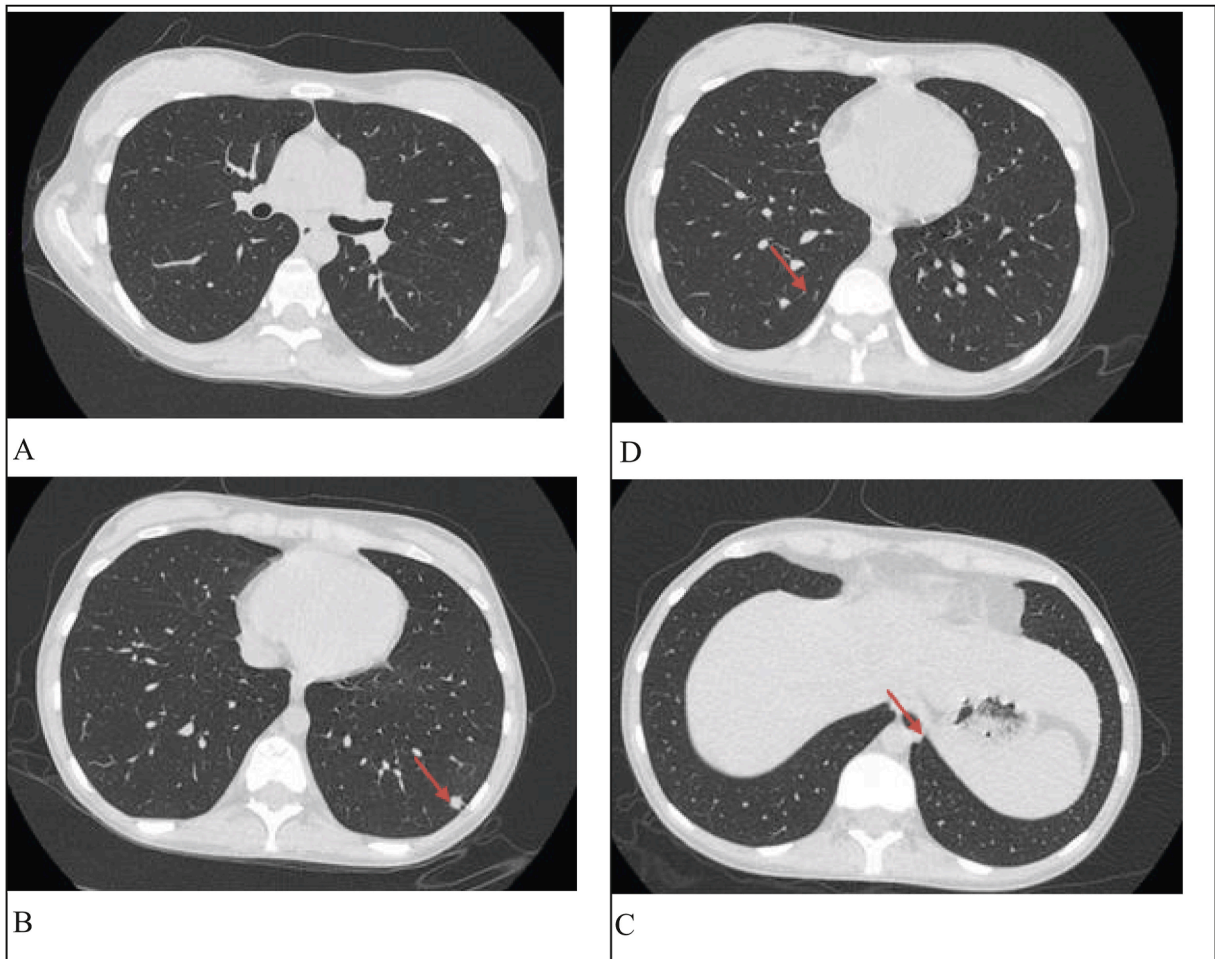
Representative images from a follow-up CT scan 8 weeks after treatment. The same levels from Fig. 1 are shown here demonstrating significant reduction in the size of most nodules and complete resolution of others.
